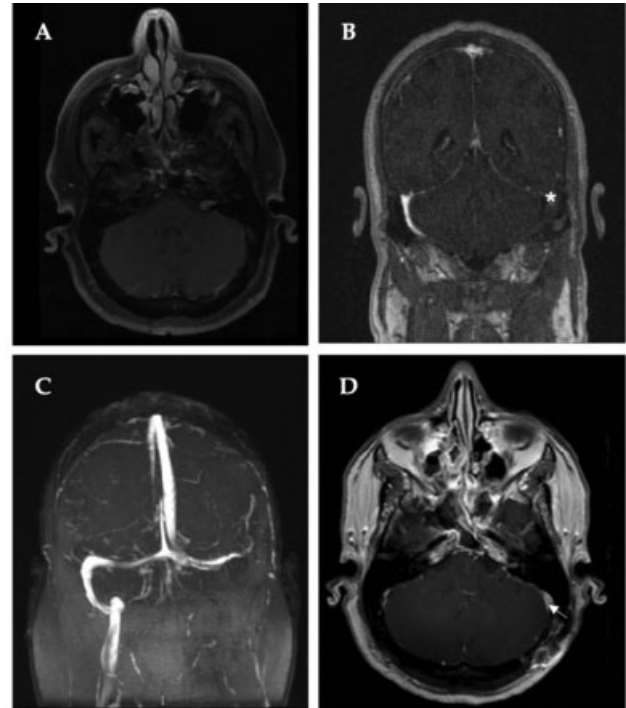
Middle aged patient who underwent uneventful retrosigmoid resection of left vestibular schwannoma (A) who was found to have filling defect (*) of the left transverse and sigmoid sinuses on routine postoperative imaging (B). (C) MRV demonstrated incidental left sigmoid and transverse sinus thrombosis. The patient was managed conservatively without anti-coagulation and (D) MRI at 6 months post-operatively demonstrated recanalization of the transverse and sigmoid sinuses with no neurological sequela (arrow).
